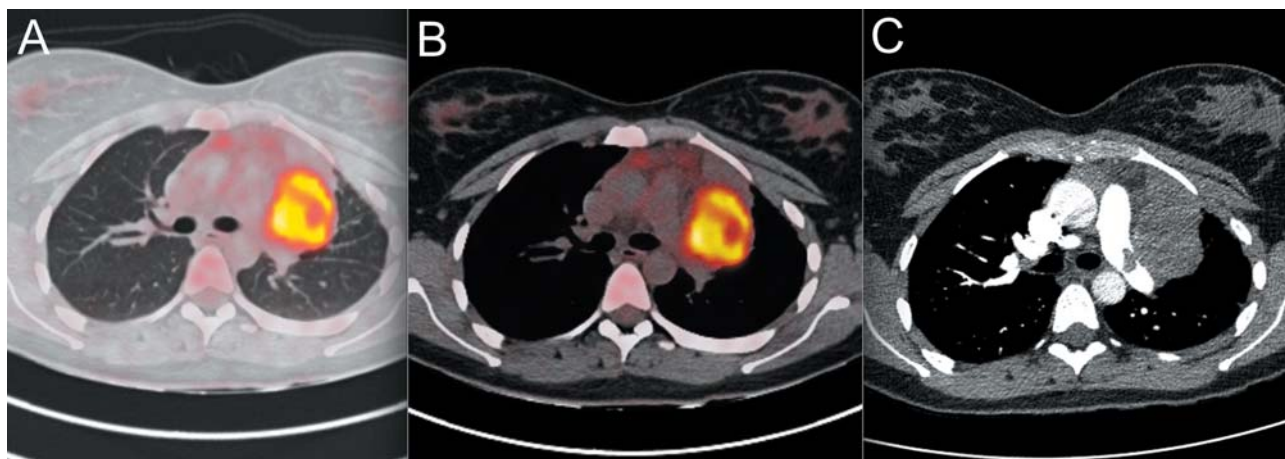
A, B: Positron-emission tomography with computed tomography scan (PET-CT) pulmonary and mediastinal window. Hypermetabolic parahilar mass of 45×55×52 mm (standard uptake value (SUV)_{max} 20.2) with an image of doubtful left pulmonary artery infiltration and soft thrombus. C: Computed tomographic scan of the pulmonary artery. Parahilar mass with left pulmonary artery infiltration and nodular intraluminal protrusion.
